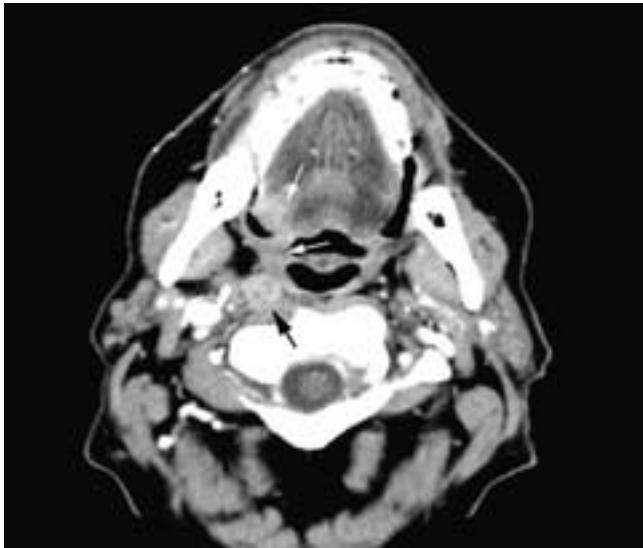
Axial contrast-enhanced CT scan shows a squamous cell carcinoma thickening the right oropharyngeal wall with extension to the right base of the tongue (white arrows). There is a nonhomogeneous right retropharyngeal node (black arrow).
